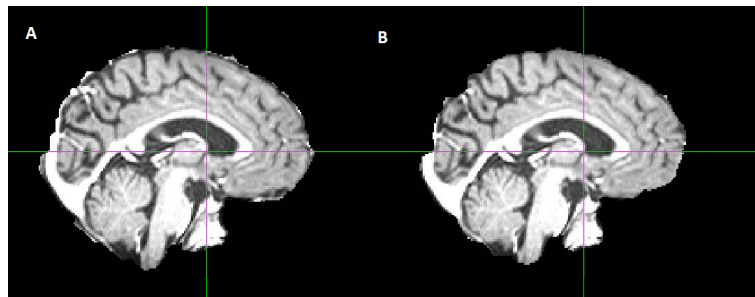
Skull-stripped pre-operative MRI from Patient 3 using A - a lower threshold and B - a higher threshold.
